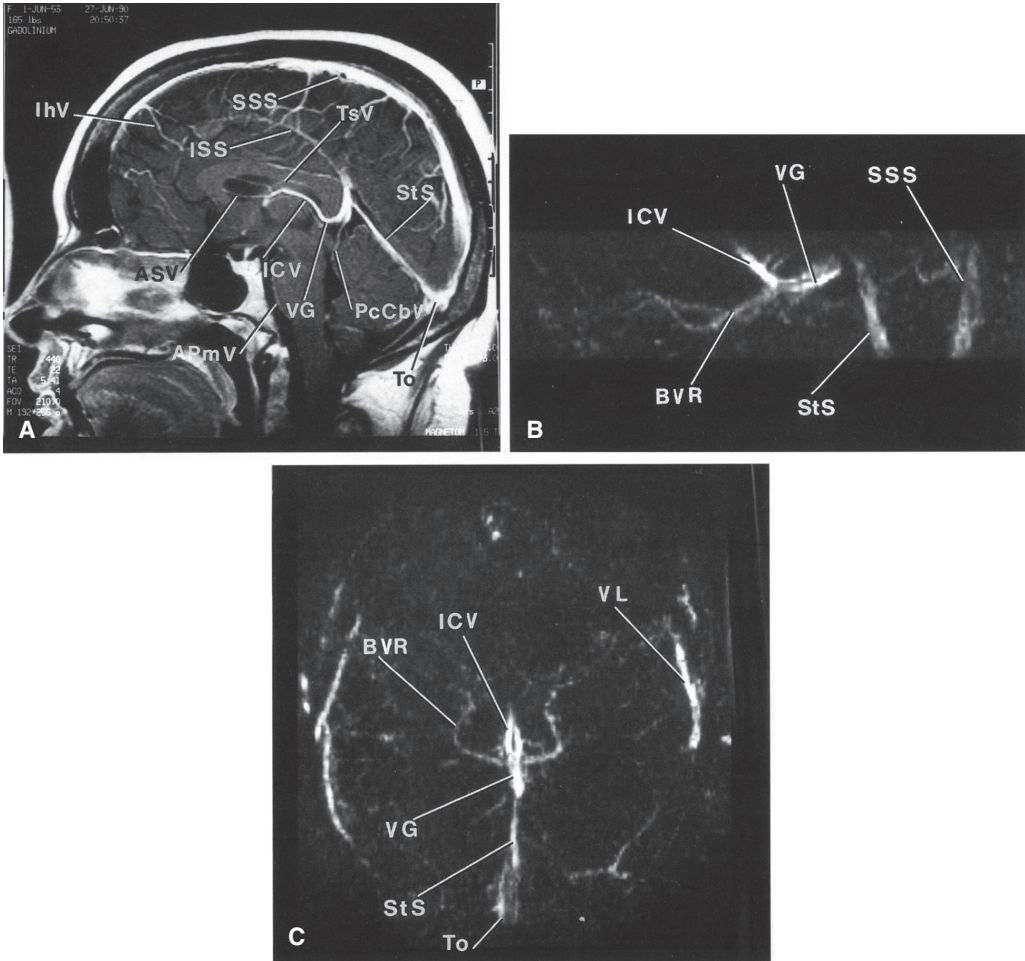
Venous anatomy of a magnetic resonance section; midsagittal (A), lateral (B), and submental–vertex (C). *IhV* = interhemispheric veins; *SSS* = straight sinus; *PcCbV* = precentral cerebellar vein; *To* = torcula; *VG* = vein of anterior pontomesencephalic veins. (Modified from Grossman CB. *Magnetic Resonance Imaging and Computed Tomography of the Head and Spine*. 2nd ed. Philadelphia, PA: Williams & Wilkins; 1996:124.)
